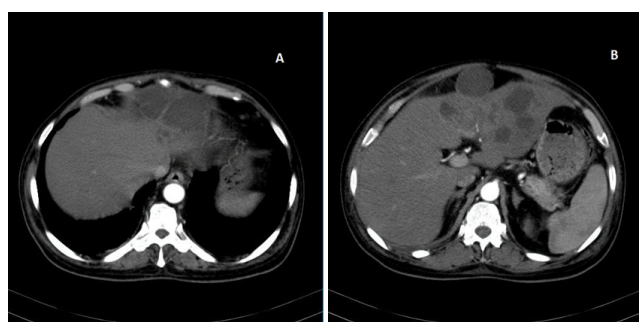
A,B- Contrast CT of the abdomen revealing a ruptured intrahepatic abscess
